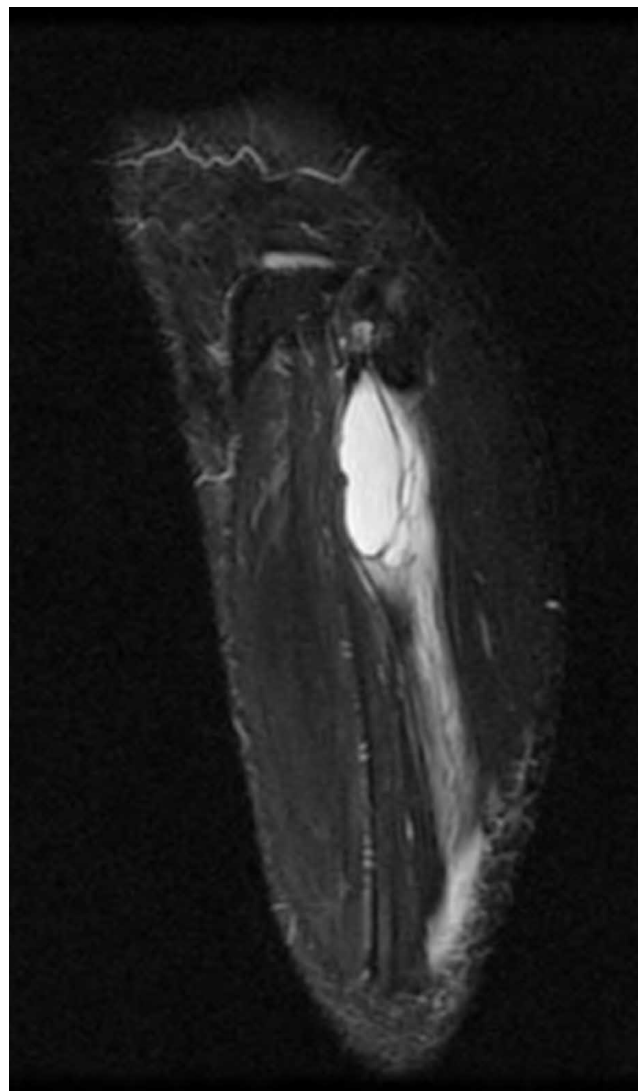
Ruptured peroneal ganglion cyst. T2 fat-saturated sagittal MRI shows a multiloculated cyst with fluid tracking distally from the lesion along fascial planes.
